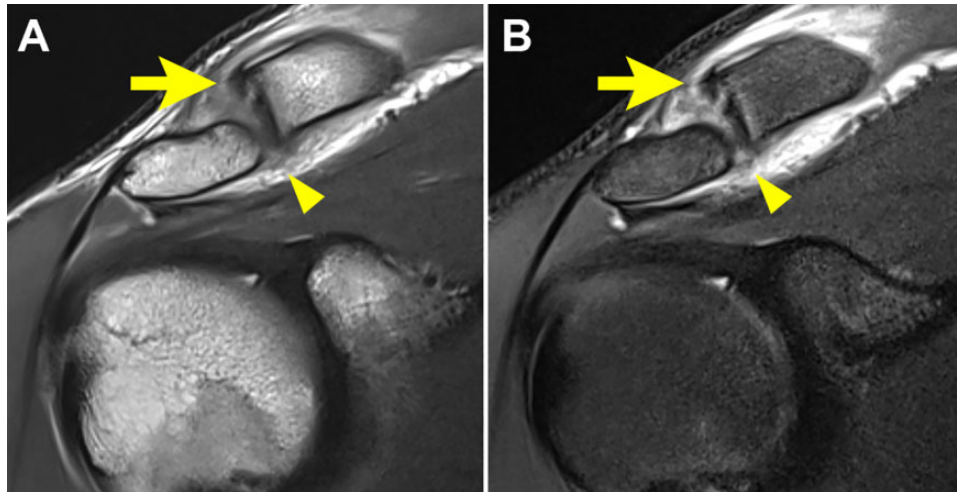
Grade 1 acromioclavicular injury. Coronal (A) intermediate and (B) T2-weighted fat-suppressed magnetic resonance imaging scans show complete disruption of the superior (arrows) and inferior (arrowheads) acromioclavicular ligaments.
